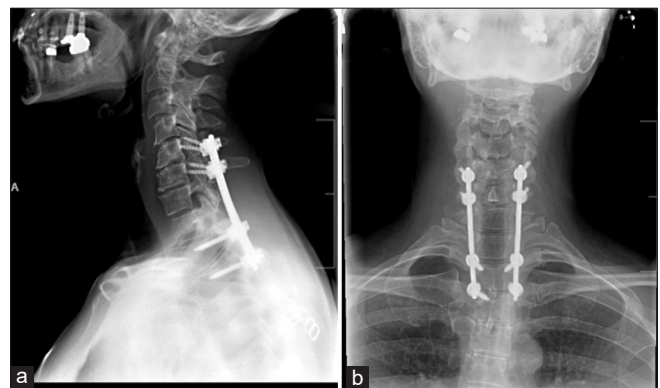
Lateral (a) and anteroposterior (b) X-rays one year after surgery show fusion and stable hardware placement.
